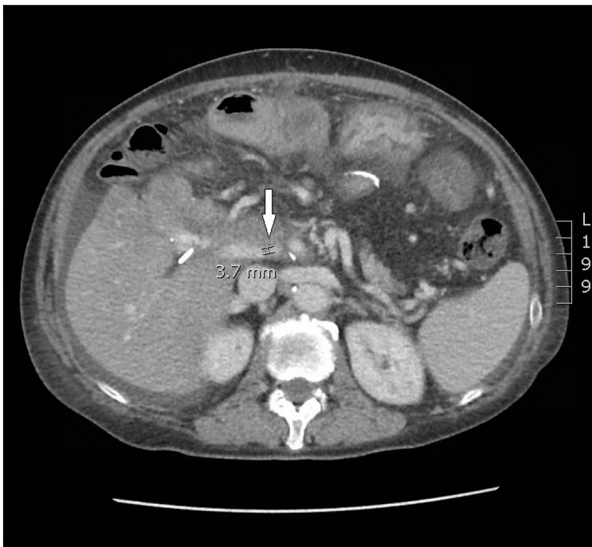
Stenosis of the portal vein to a diameter of 3.7 mm on the axial section of computed tomography abdomen (white arrow).
